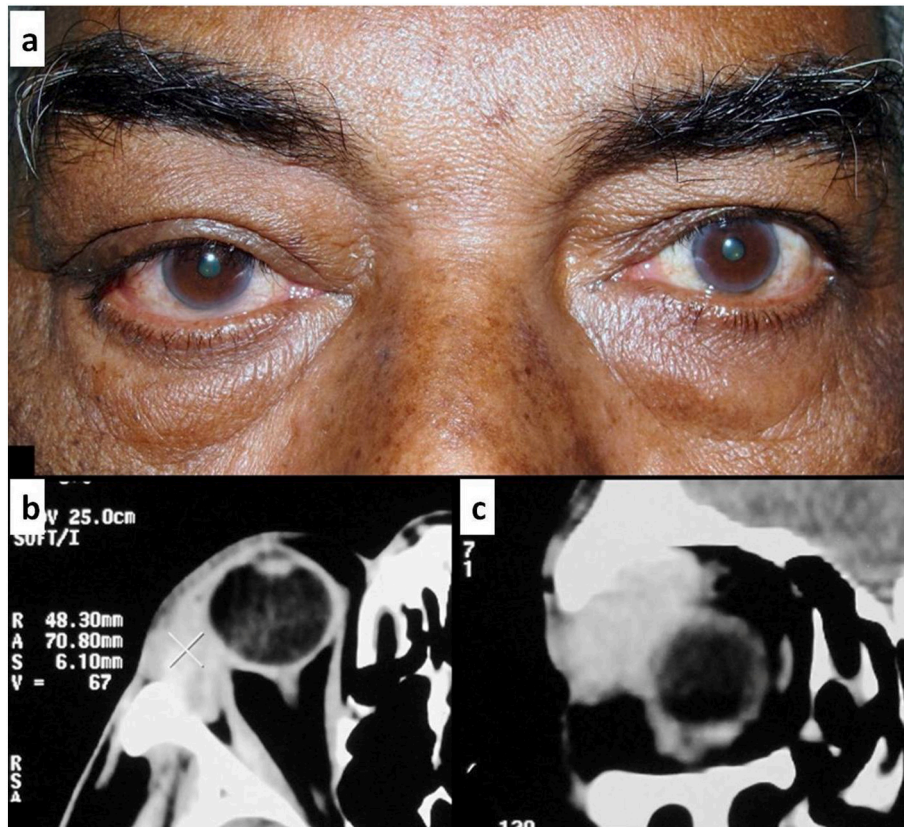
Clinico radiological features of Case 1. Clinical examination revealed subtle right temporal upper eyelid fullness with minimal proptosis and slight inferior globe displacement (a). Imaging by CT showed a heterogeneous right lacrimal gland mass lesion with slightly irregular but well-defined borders (b, c). No changes were obvious in the adjacent bone.
